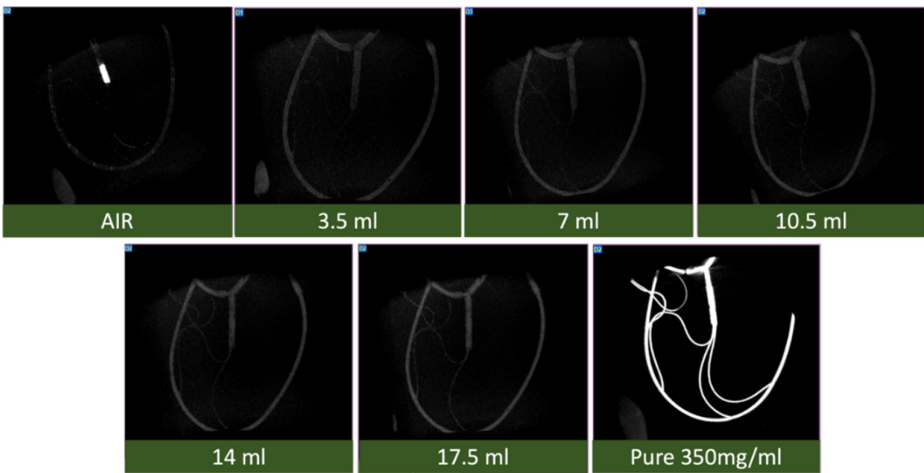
CBCT images for different iodine concentrations.
